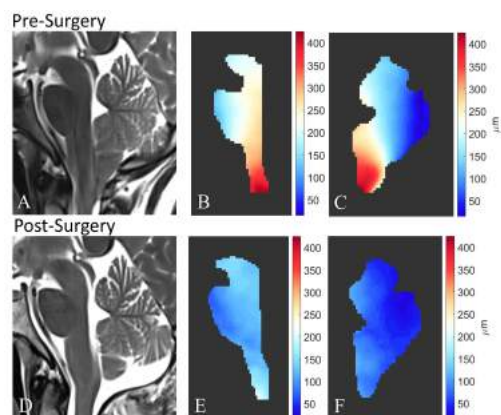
High-resolution T2-weighted images (A) before and (D) after surgery, and peak magnitude displacement maps of one participant before and after surgery. (B & E) Brainstem displacement maps and (C & F) cerebellar displacement maps.
